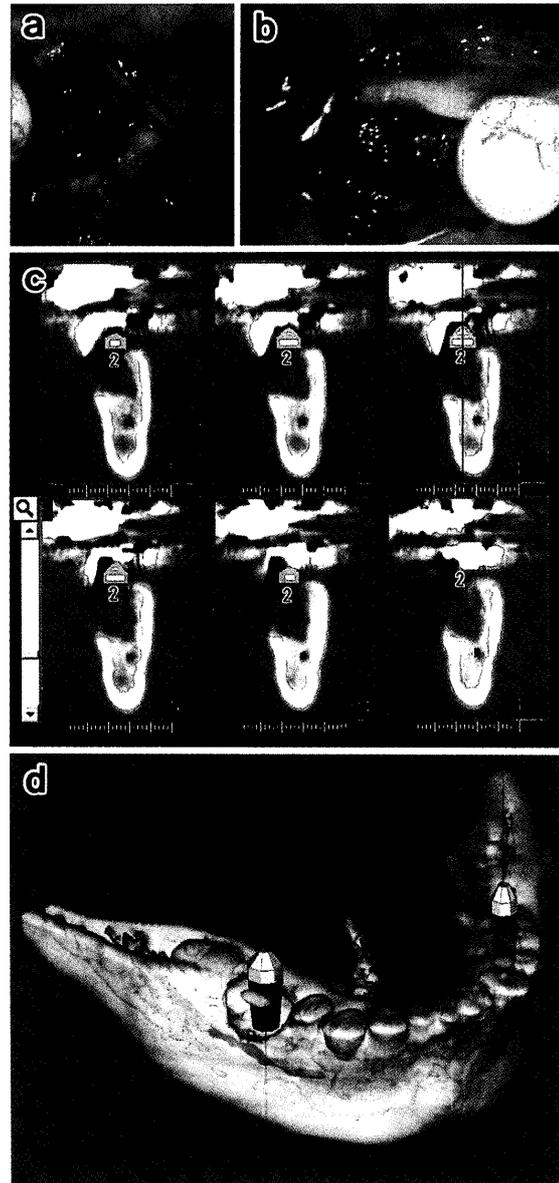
Photographs before operation (a) and 6 months after operation (b), CT (c) and 3D (d) images of the defect from Patient 1 before operation. Severe chronic periodontitis and a large alveolar bone defect are evident in the right mandibular first molar.
